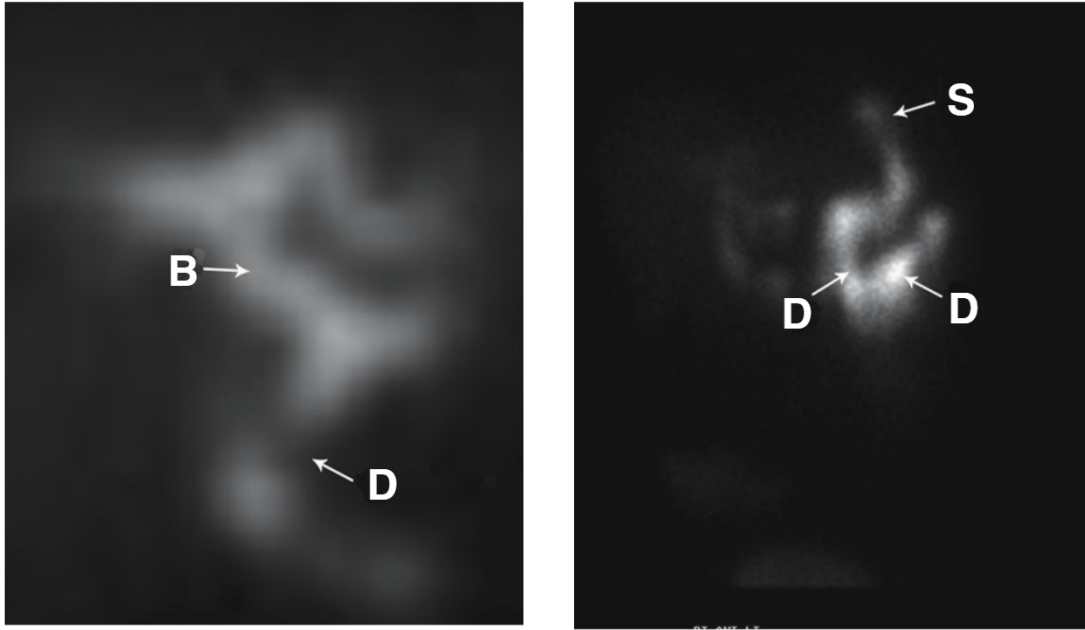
Hepatobiliary scintigraphy showed normal duodenum (D) and biliary tree (B) and reflux of the technetium Tc99m into an atonic bypassed stomach (S).
